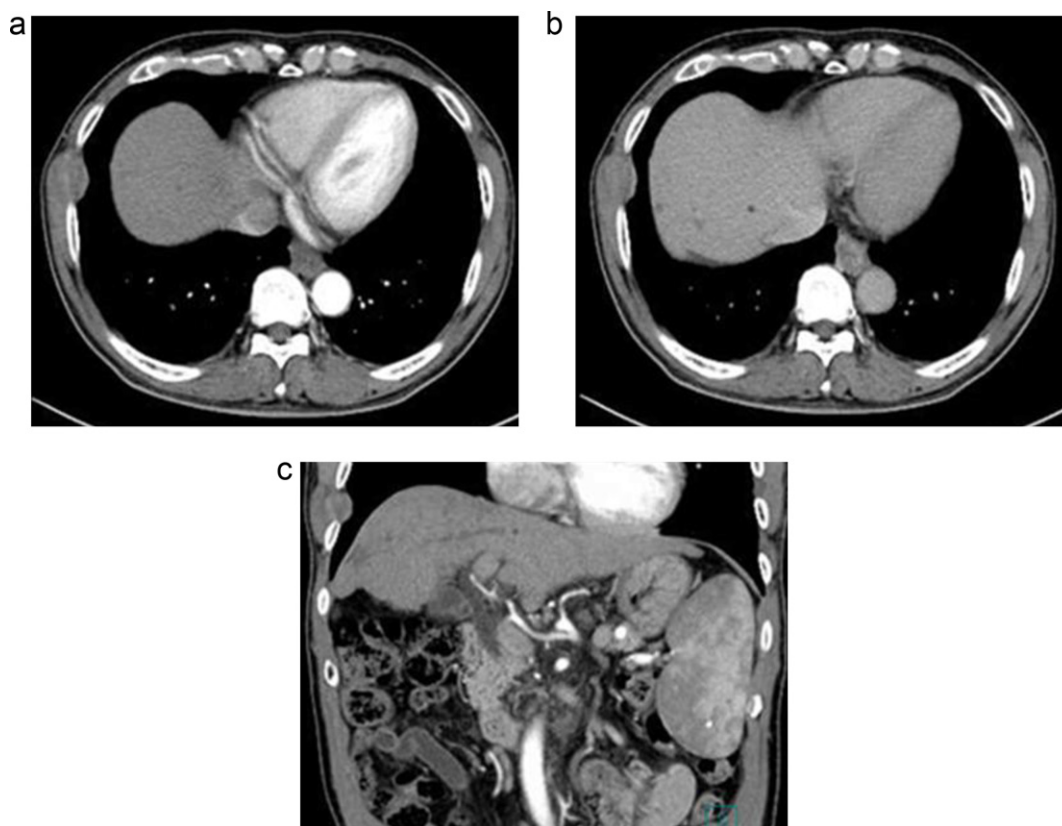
Contrast-enhanced CT revealed a right chest wall mass that was heterogeneous and weakly enhanced in both early (arterial) (a, c) and late (b) phases.
